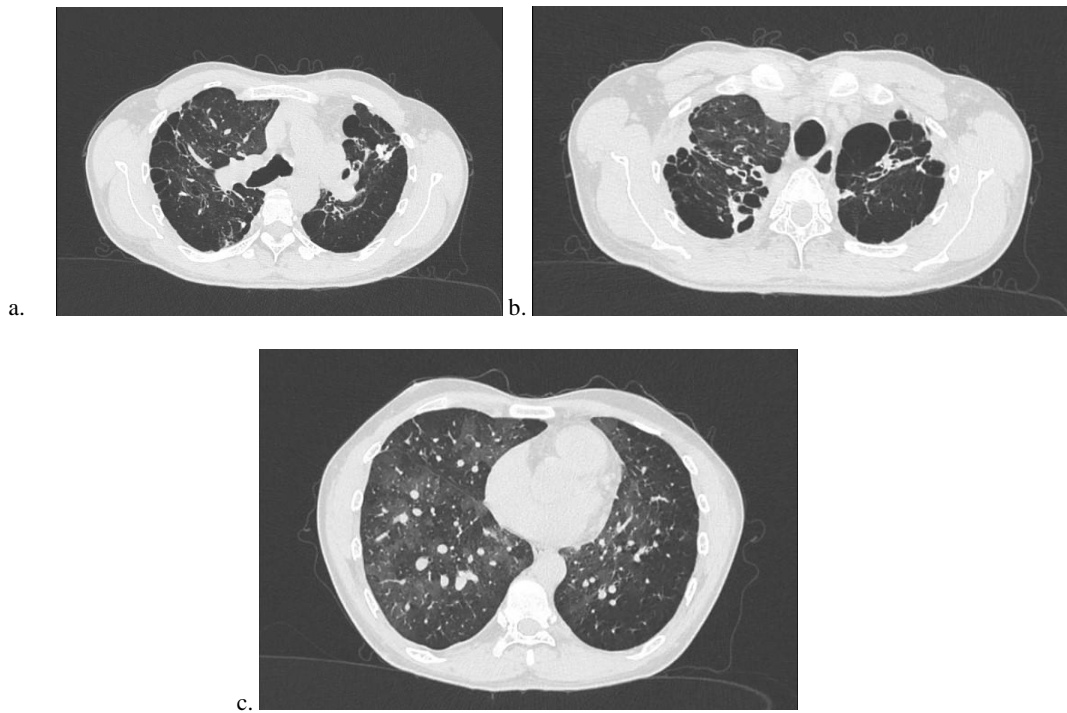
High-resolution computed tomography (HRCT) (a) showed dominant bullae and panlobular emphysema; (b) showed dominant fibrosis, traction bronchiectasis, and a reticular pattern; (c) showed dominant ground-glass opacities, some calcification, and a mosaic attenuation pattern.
